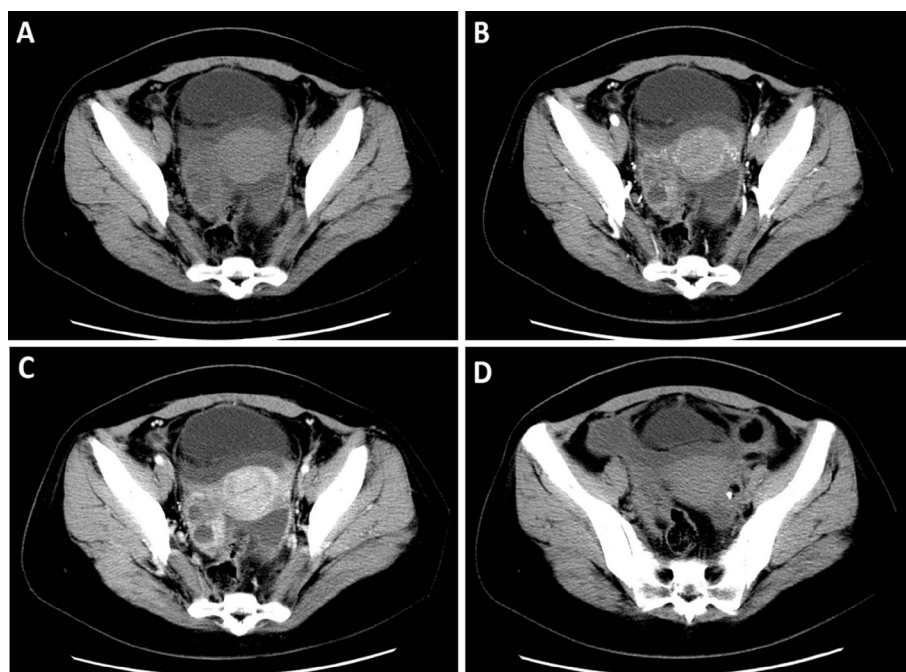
A 29-year-old female with pelvic tuberculosis. Non-enhanced CT scan of the abdomen and pelvis shows an ovoid, ill-defined, mixed (solid and cystic) mass arising from the right adnexa measuring  $4.3 \times 3.4$  cm (A). Contrast-enhanced CT scan shows multilocular caseous necrotic enhancement in arterial phase (B), and venous phase (C). Left adnexal mass ( $5.0 \times 2.5$  cm) with a focal nodular shadow of fat density (CT value of about  $-72$ HU) and calcification (D). This patient also showed high density ascites, smoothly thickened and enhanced peritoneum.
